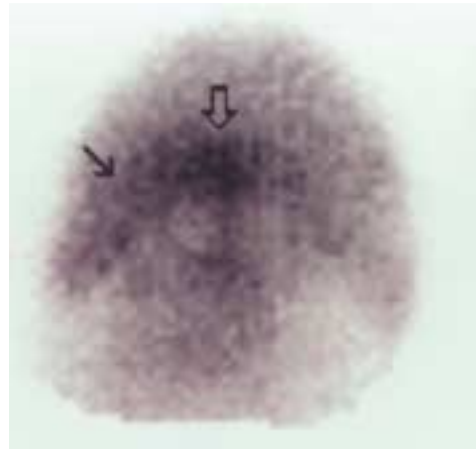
Solar scintigraphic bone phase image of the left front foot of Case 2. Medial is to the left. Intense focal uptake is evident in the region of insertion of the DDFT on the left distal phalanx (large arrow). Diffuse moderate IRU is present in the medial palmar part of the distal phalanx (small arrow).
